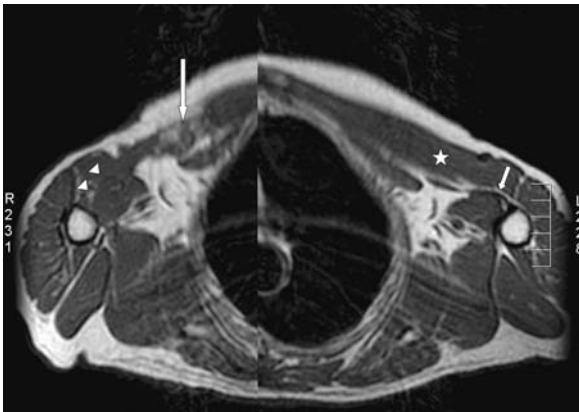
Composed axial T1-weighted image of the right and left shoulder. The injury to the pectoralis major muscle in the right shoulder is well appreciated (*longer white arrow*) compared to the uninjured left shoulder (*white asterisk*). In the uninjured shoulder the tendon of the pectoralis muscle is seen anterior of the coracobrachialis muscle (*short white arrow*); in the injured shoulder the tendon is absent and the normal fatplane is not seen (*arrowheads*).
